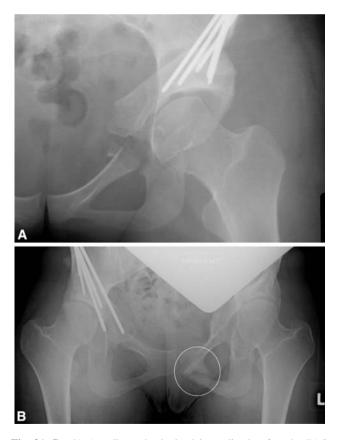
B (A) A radiograph obtained immediately after the PAO shows an intact inferior ramus. (B) An anteroposterior radiograph shows an inferior pubic ramus fracture after periacetabular osteotomy.
